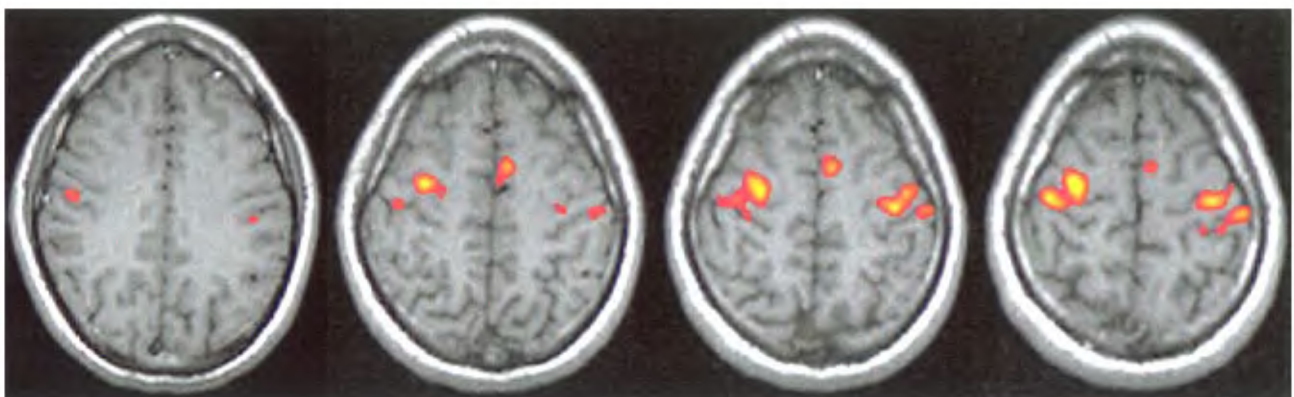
Functional MR image of a volunteer carrying out finger movements of the both the hands simultaneously. The appropriate cortical activity in the left and right motor area in different slices is shown as hyper-intense signal on a T1-weighted axial MR image.
